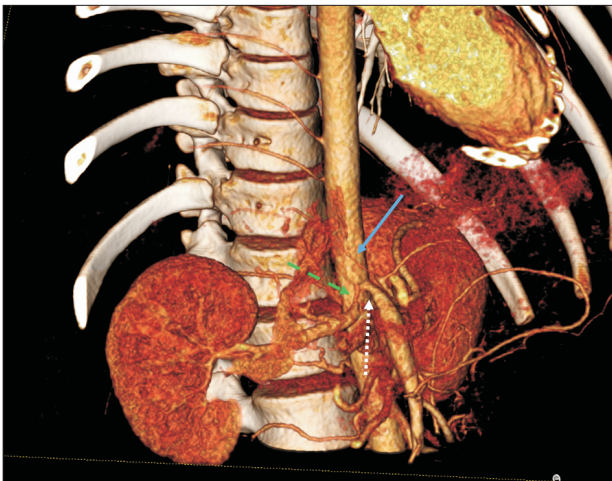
Computed tomography 3D reconstruction depicted median arcuate ligament syndrome with celiac axis occlusion (blue arrow), 50% stenotic superior mesenteric artery (white dotted arrow), and tight stenosis of the right renal artery ostium (green dashed arrow).
